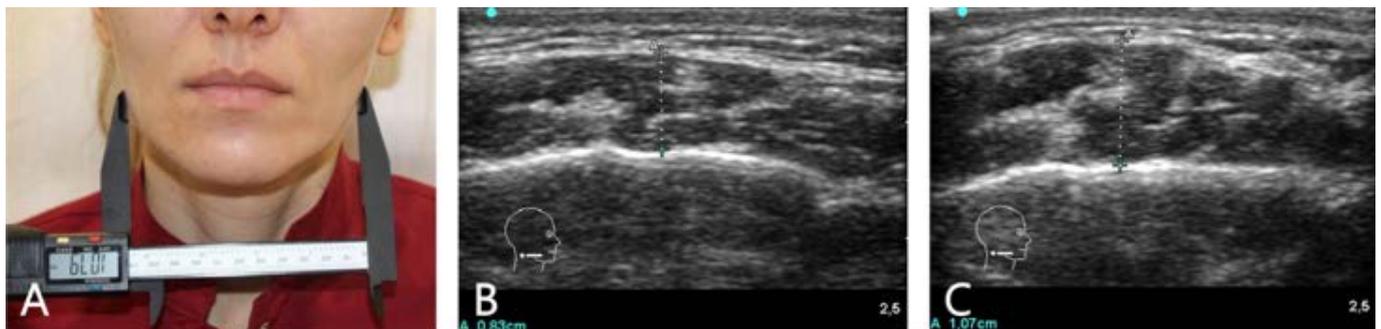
Study patient no. 6 (36 years old) A. Modified bigonial diameter obtained using a digital spreading caliper. B. Measurements taken by ultrasound of the right masseter muscle at rest and during contraction of the same patient.
